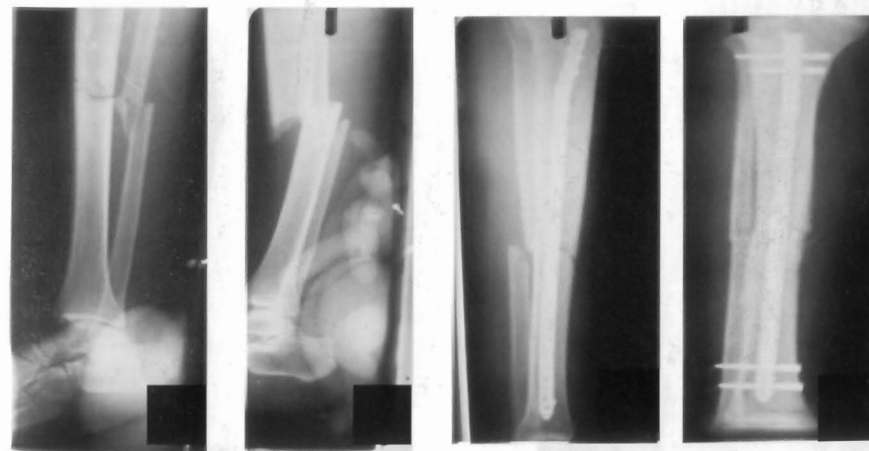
Pre op (A and B) and Post closed reduction and nailing (C and D) radiographs of transverse tibia fracture.
